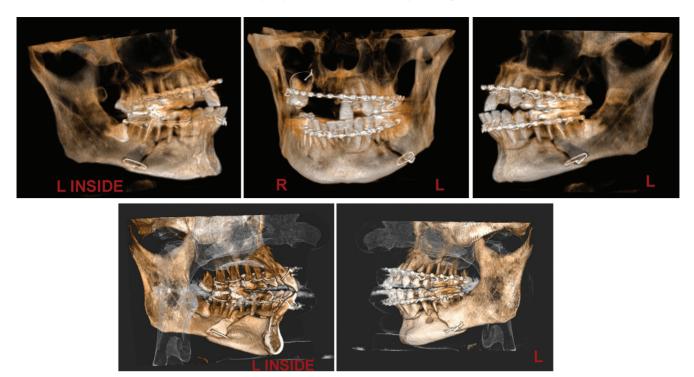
Cone Beam Computer Tomography of the mandible and maxilla.
